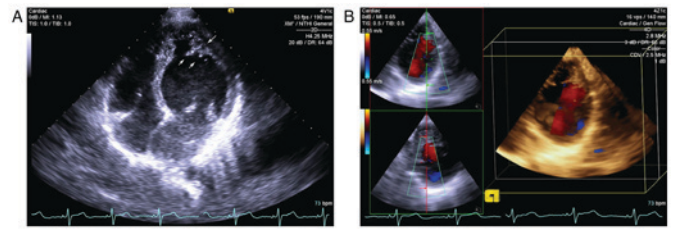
Echocardiography of the proband. (A) Apical four-chamber view of a two-dimensional echocardiogram of the proband revealing a thickened endocardial layer (short arrows) with prominent trabeculations and deep recesses, in addition to a thin epicardial layer (long arrow). (B) Apical 2-chamber view of a four-dimensional echocardiogram of the proband, demonstrating blood flow from the ventricular cavity into the deep recesses.
